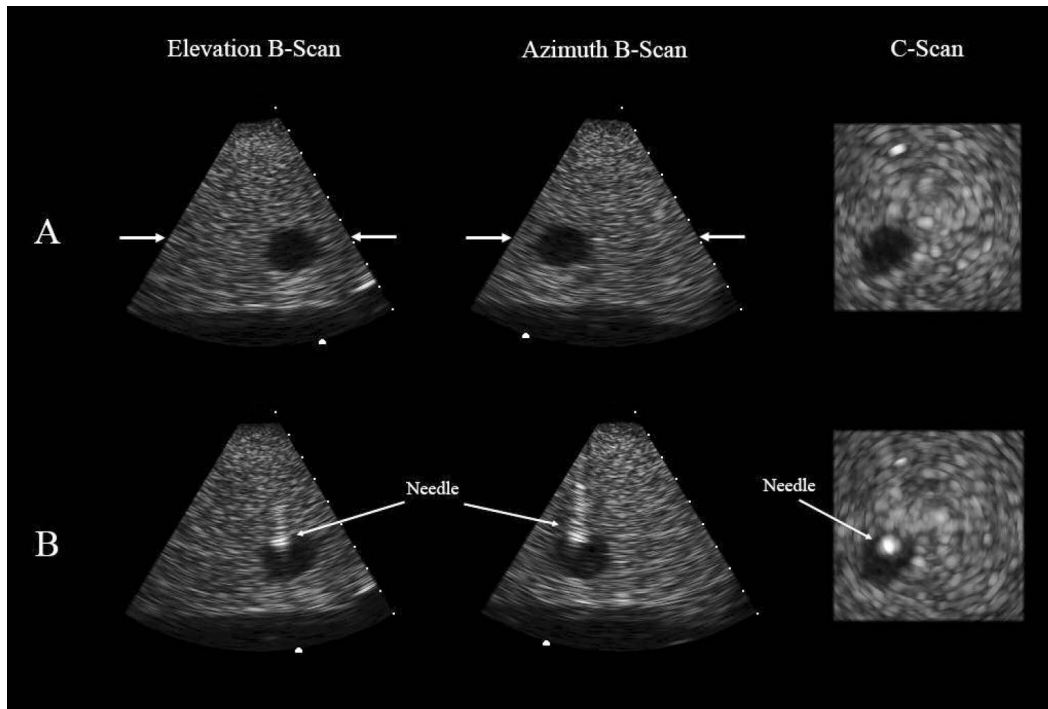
Integrated 3-D ultrasound guidance and robotics for a hypoechoic lesion in a tissue-mimicking medium. The lesion's coordinates are measured from the B-scans and C-scan in (A). In (B), the needle is coming into contact with the lesion.
